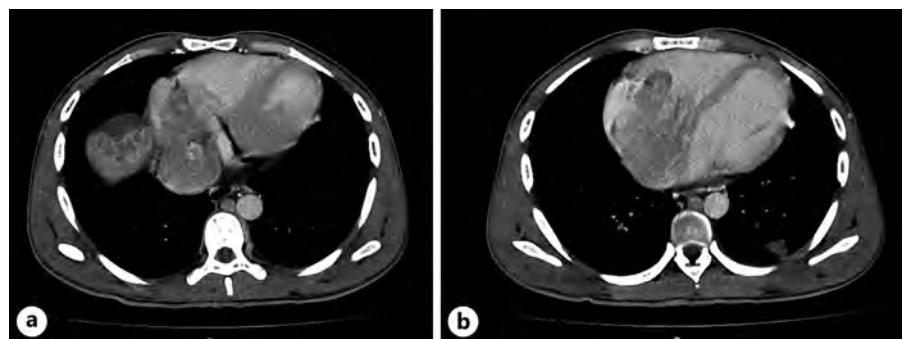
CT scan of the thorax. a Macrovascular invasion of the left portal vein, middle suprahepatic veins, and inferior vena cava. b Tumoral extension into the lumen of the right ventricle and atrium, with an intracardiac component measuring $9 \times 7.5 \times 6$ mm (AP \times T \times L). CT, computed tomography.
